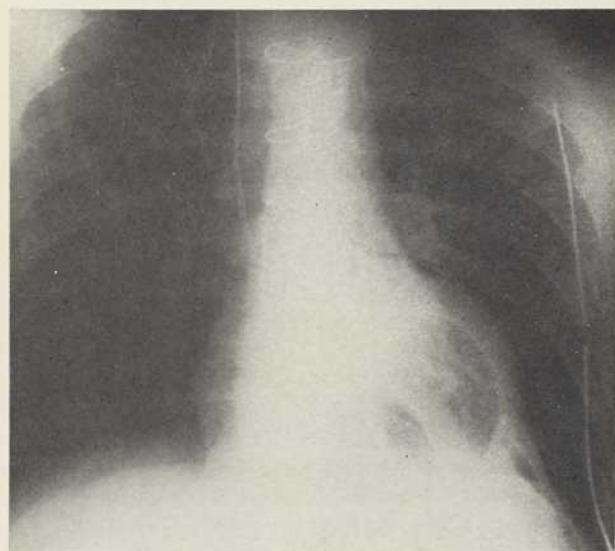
Roentgenogram of the same patient 36 hours after insertion of prosthesis, revealing unusually normal cardiac contour with double gas shadow indicating that the pumps were in systolic phase.
